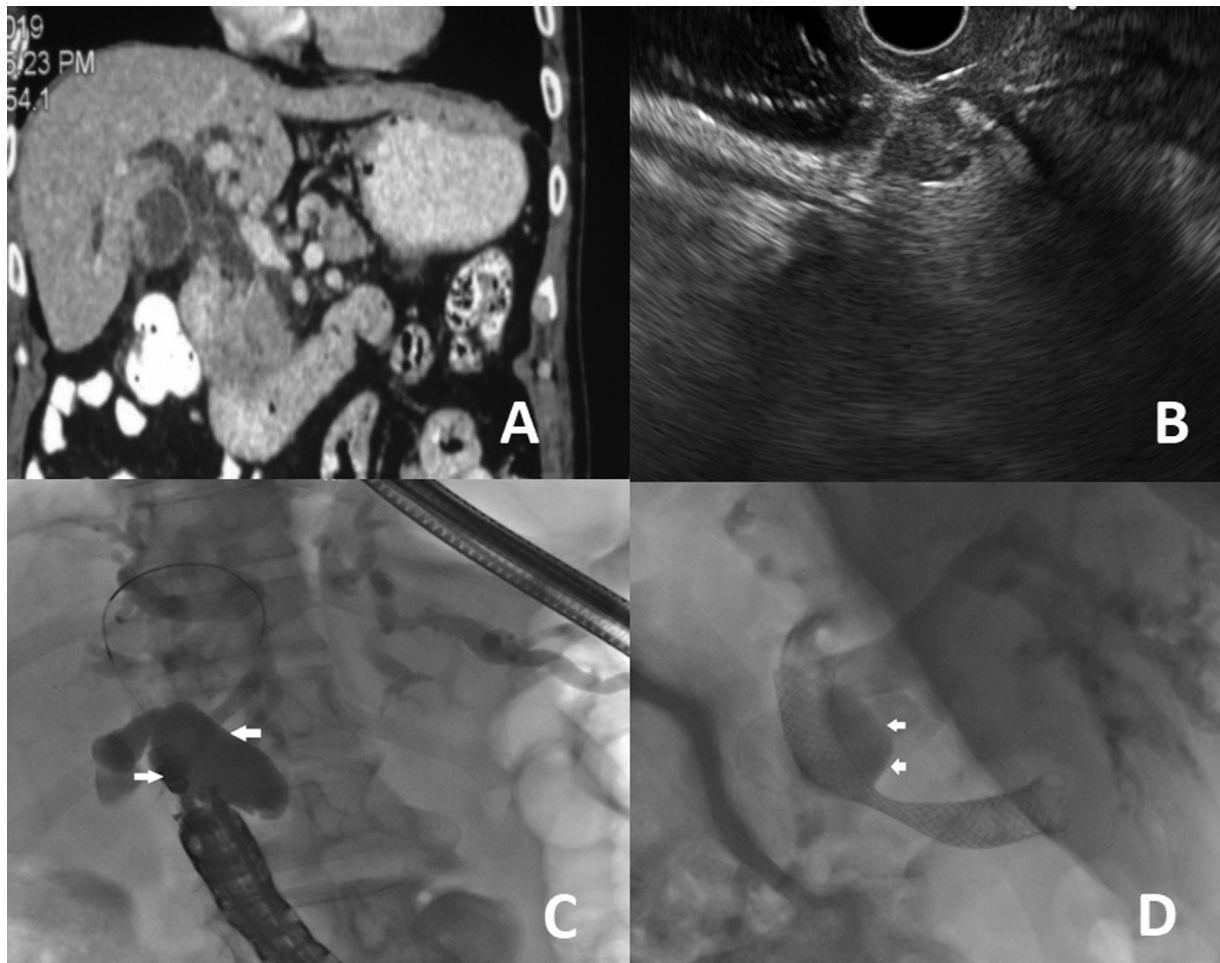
Fatal acute cholecystitis post-endoscopic ultrasound-guided choledochoduodenostomy (EUS CDS). (A) Contrast-enhanced computed tomography abdomen: Mass in the head of pancreas causing lower common bile duct obstruction. (B) EUS CDS being performed. Guide wire negotiated deep into bile duct. (C) EUS CDS: Guide wire negotiated deep into left ductal system. Gallbladder filled with contrast noted (arrows). (D) Delayed emptying of contrast from the gallbladder (arrows).
